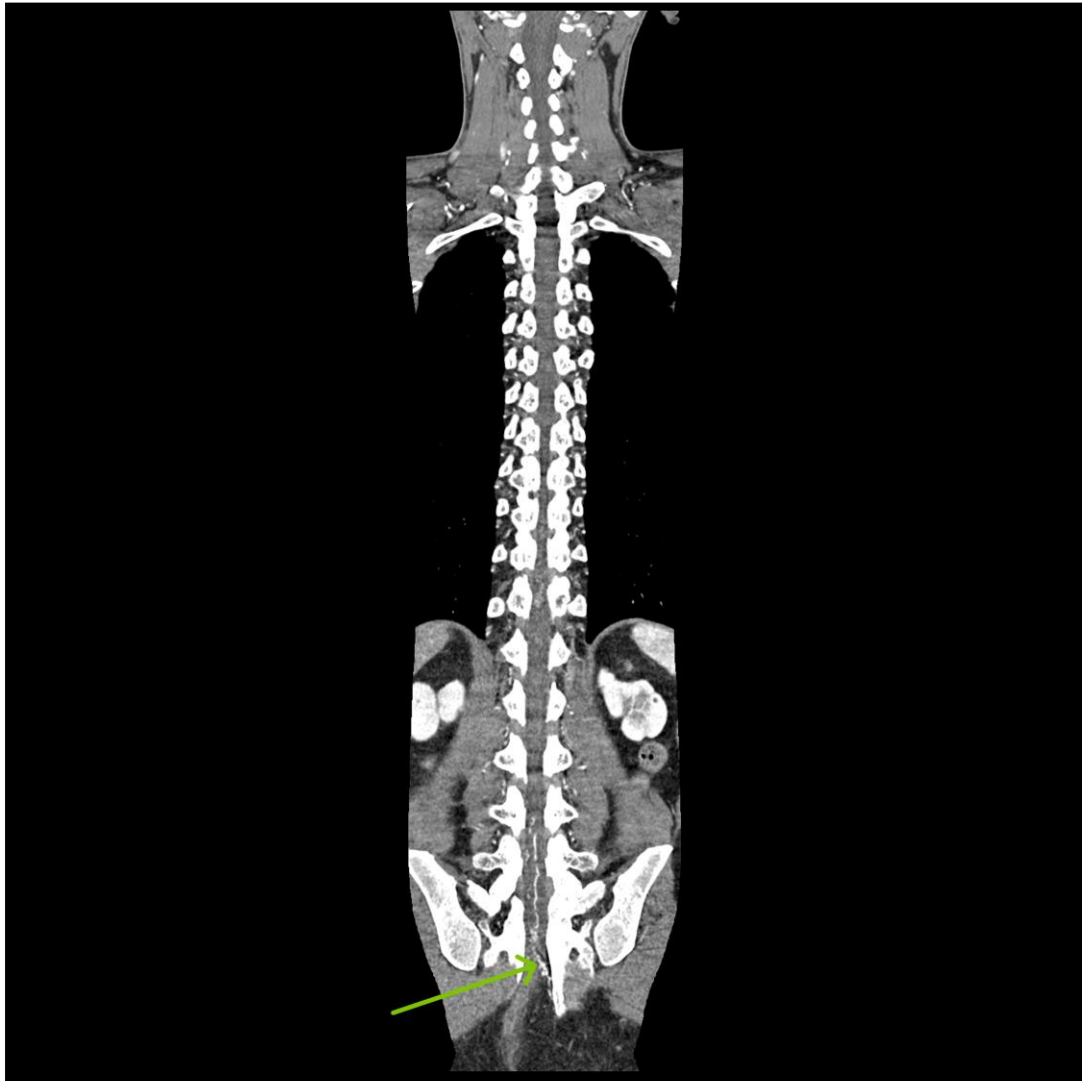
CT Angiogram image of the spine.
